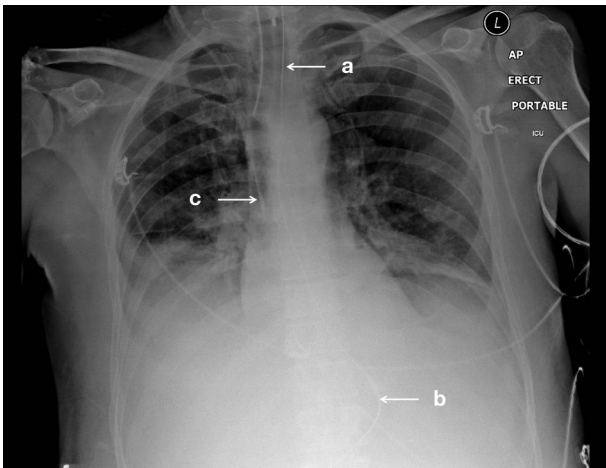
AP portable chest X-ray of a sick patient in ICU. Note the positions of the (a) ET tube, (b) NG tube and (c) internal jugular line.
